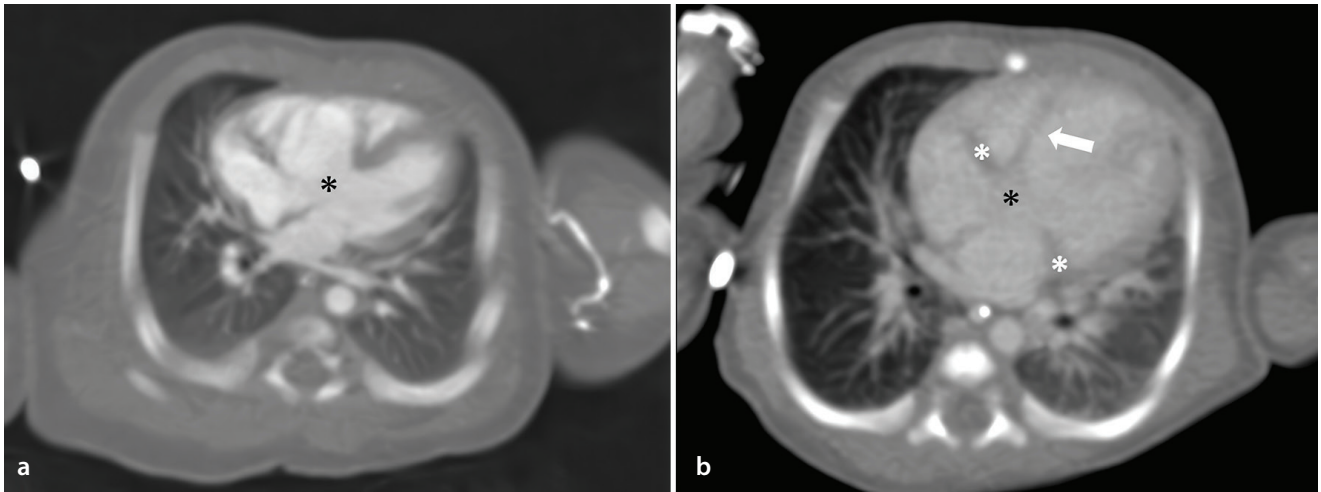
Axial computed tomography angiography images: (a) perimembranous-type (black star) and (b) muscular-type ventricular septal defects.
